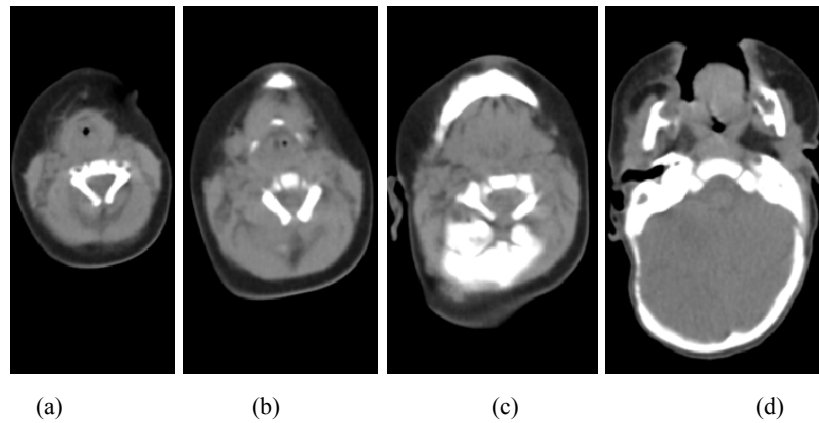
Example of CT slices of a patient without PRS
